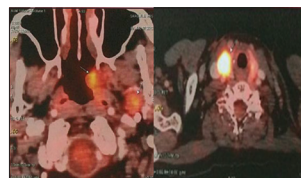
Positron-emission tomography-computed tomography showing uptake in the left nasopharynx, left infratemporal fossa, and right thyroid lobe
